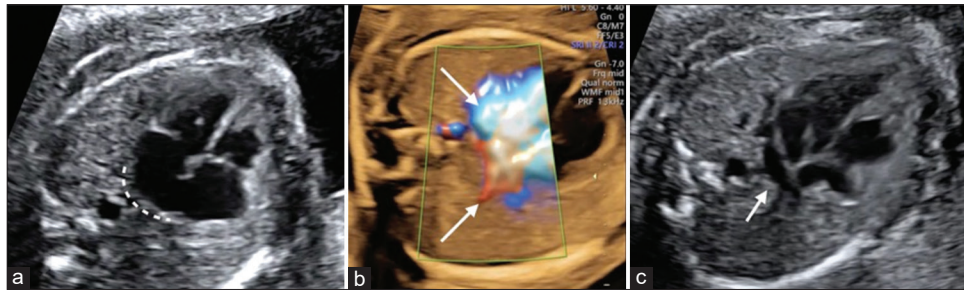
Direct sonographic markers for fetal total anomalous pulmonary venous return. (a) The smooth posterior wall of the left atrium at 24 weeks of gestation in the absence of pulmonary venous entry into the left atrium, (b) color Doppler imaging cannot be used in isolation to confirm pulmonary venous entry into the left atrium. For example, in the presented case at 26 weeks of gestation, when applying the color Doppler, the pulmonary veins seemed to enter the left atrium, but B-mode image, (c) a pulmonary venous confluent chamber (twig sign) (arrow) behind the left atrium
